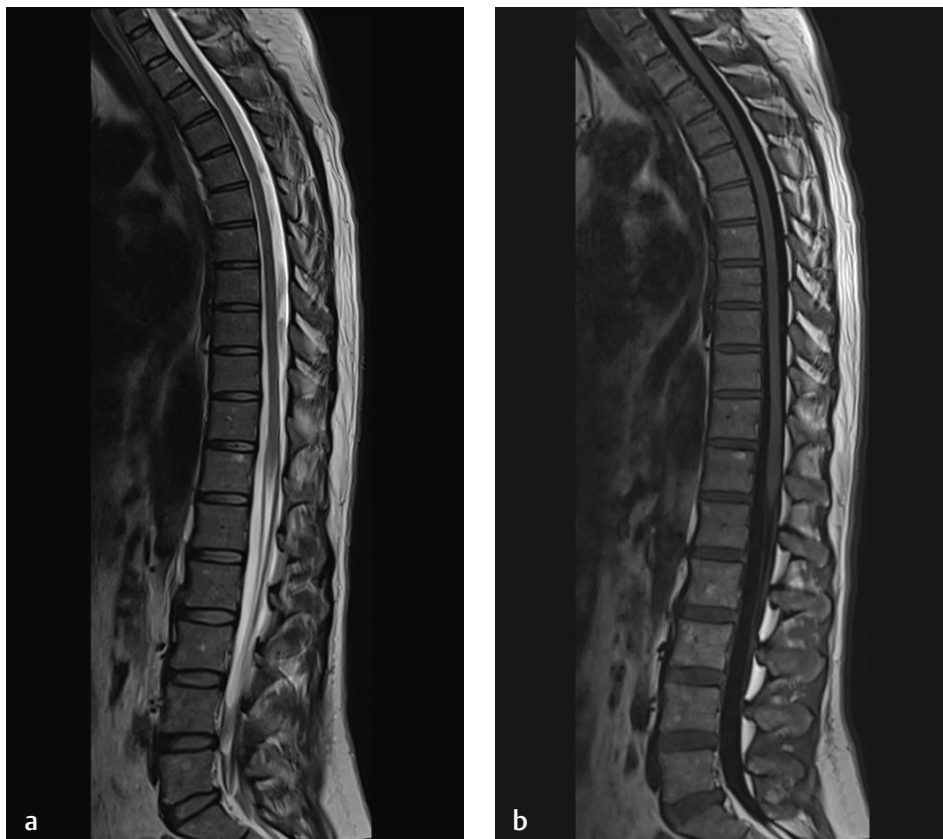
High-resolution 3D imaging of the whole spine using 3.0-T MR imaging with a 24-channel matrix coil. (a) A sagittal T2-weighted TSE image (3-mm slice thickness) acquired in two 32-cm field-of-view steps with 5 min, 36 sec total acquisition time. (b) A sagittal T1-weighted turbo inversion recovery image (3-mm slice thickness) acquired in two 32-cm field-of-view steps with 9 min, 8 sec total acquisition time, with the parallel acquisition technique, an MRI method that combines signals from several coil elements to reconstruct an image, thereby shortening the total acquisition time or improving the signal-to-noise ratio.
